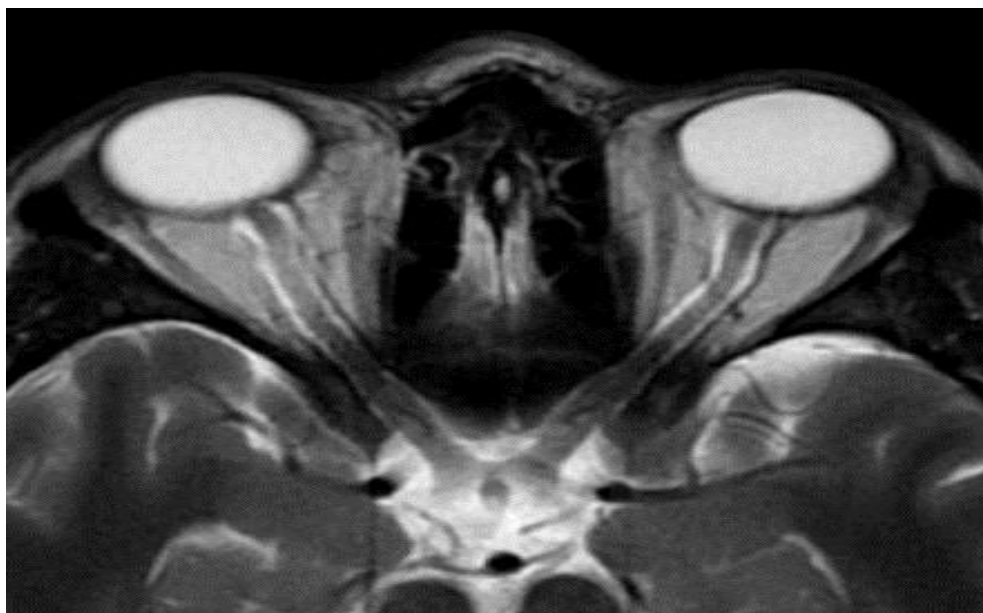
2.23 Shows axial MRI STIR for Optic Nerve and Chiasm
